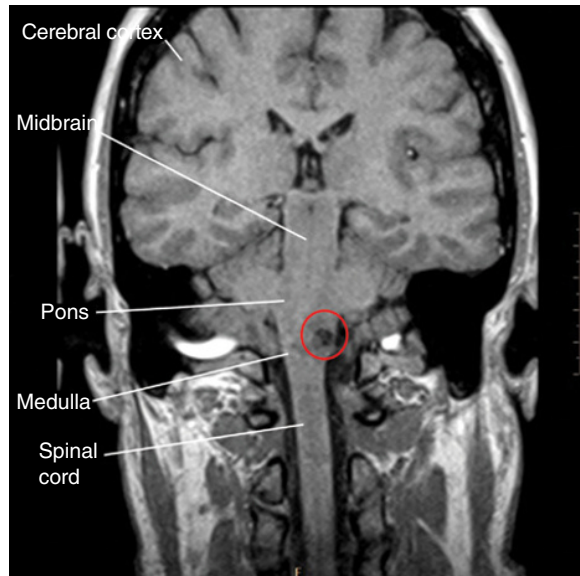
Coronal MRI image (imagine the patient looking at you) of a patient with an ischemic stroke on the left at the border between the pons and medulla in the brainstem. The darkened area within the red circle indicates an area of brain tissue necrosis (tissue death).
